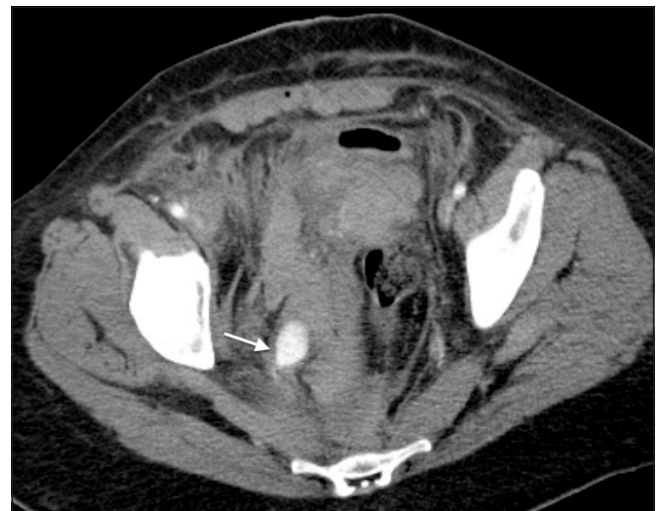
CTA demonstrates a vascular "blush" of a 2cm pseudoaneurysm and active extravasation from a branch of the right internal iliac artery (white arrow).
